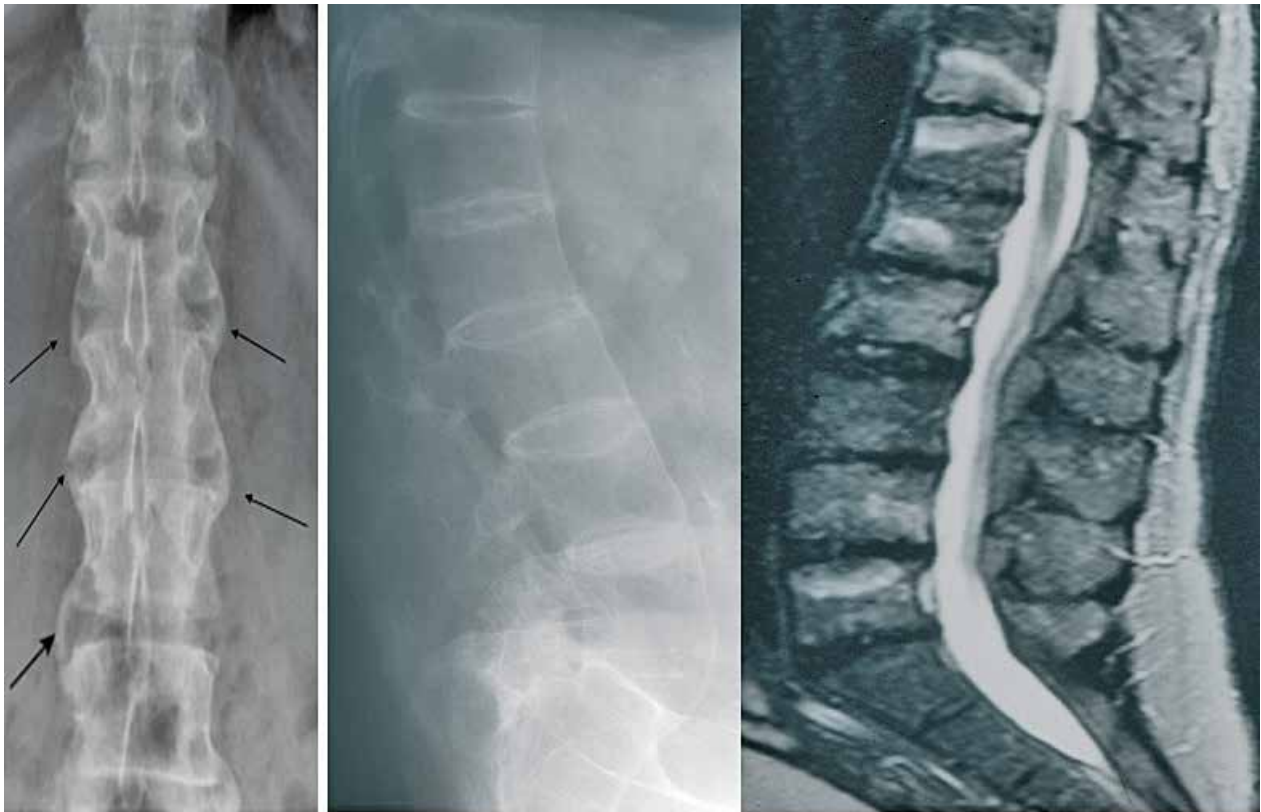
X-ray of patient with AS showing Syndesmophytes (arrows) (left) and middle resulting in bamboo spine. Right sided T2 weighted MRI image showing spondylitis and spondylodiscitis
